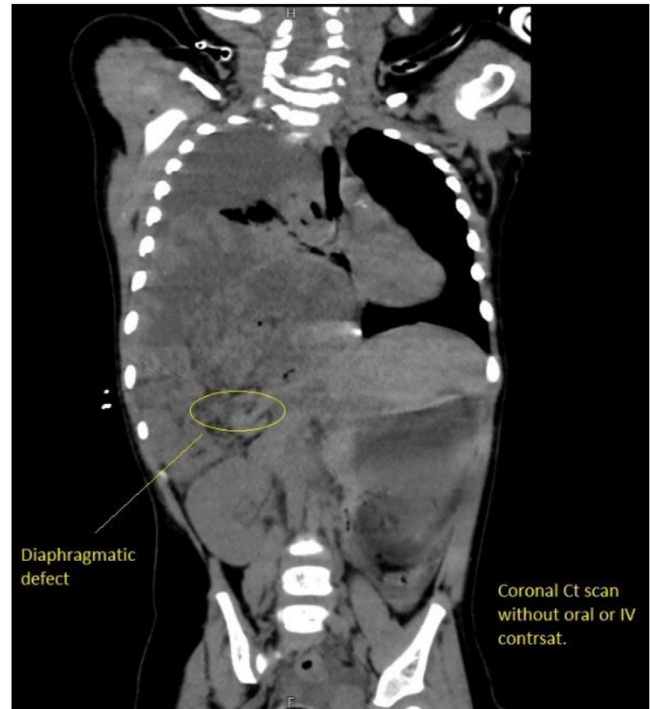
Coronal CT shows diaphragmatic defect.
